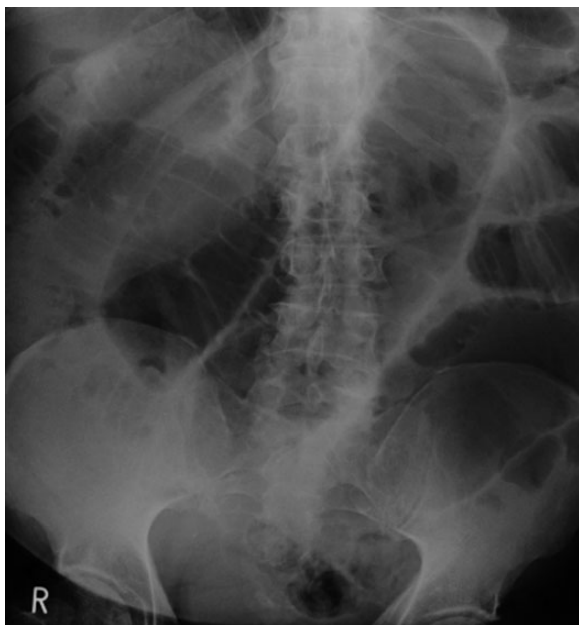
Abdominal X-ray showing SBO.
